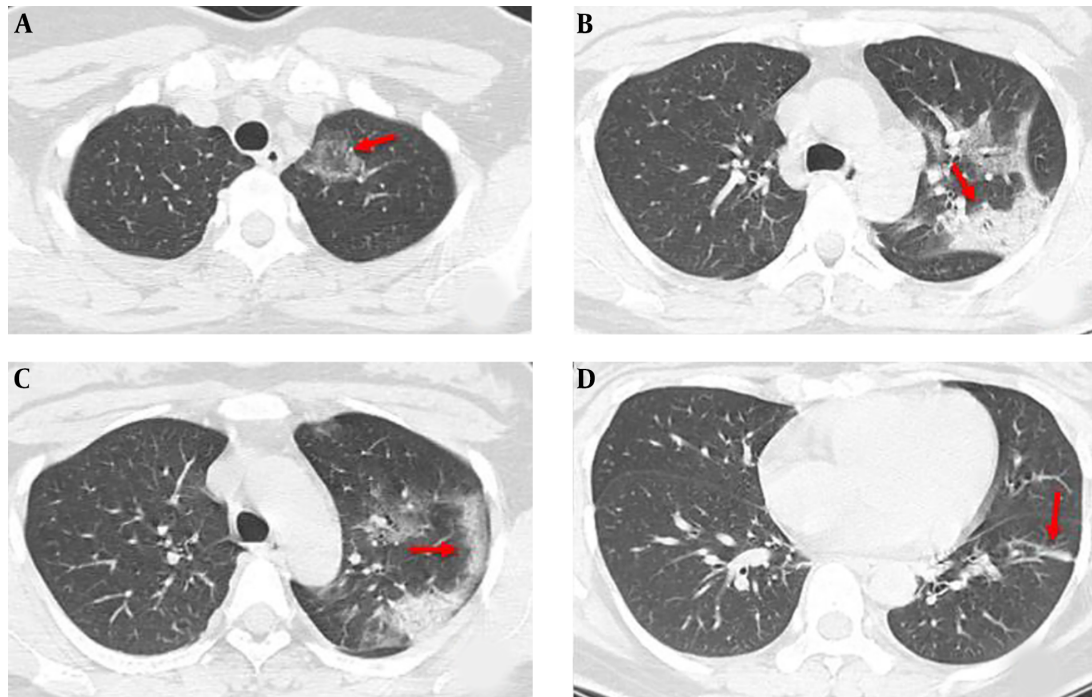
Female, 67 years old, came from Wuhan city, close contact time is not clear, have a fever for one day. There is a patchy ground-glass shadow in the upper lobe of the left lung, showing an anti-halo sign (A). The lesion showed consolidation of the lung (B). Subpleural mixed ground-glass opacity, interlobular septum thickening, with "crazy-paving pattern" (C). Left lower lobe fibrous cord shadow (red arrow) (D). (all CT images window level-600 and window width-1600).
